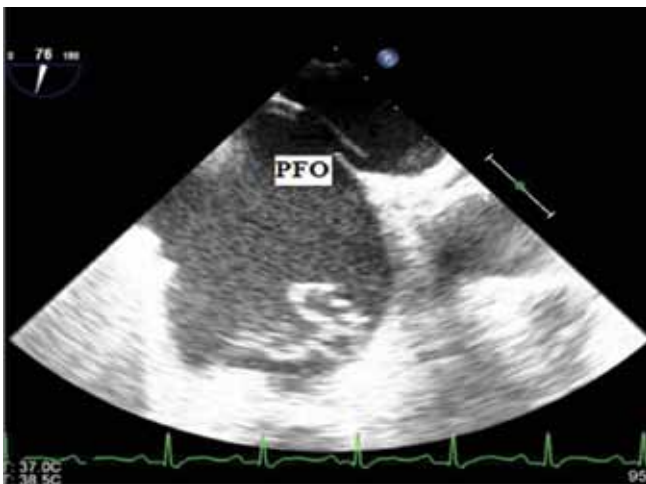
A transoesophageal echocardiography (TEE) showing patent foramen ovale and a prolapse of the anterior leaflet. RV: right ventricle, RA: right atrium, PFO: patent foramen ovale.
